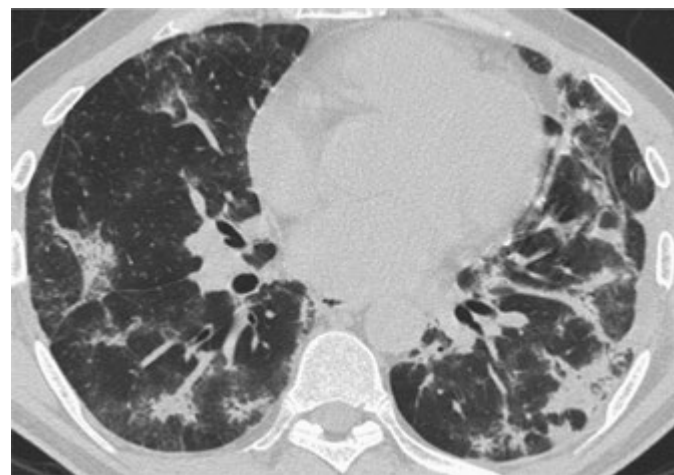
High-resolution CT scan in a patient with organizing pneumonia. There is bilateral multifocal consolidation which is most prominent subpleurally.
